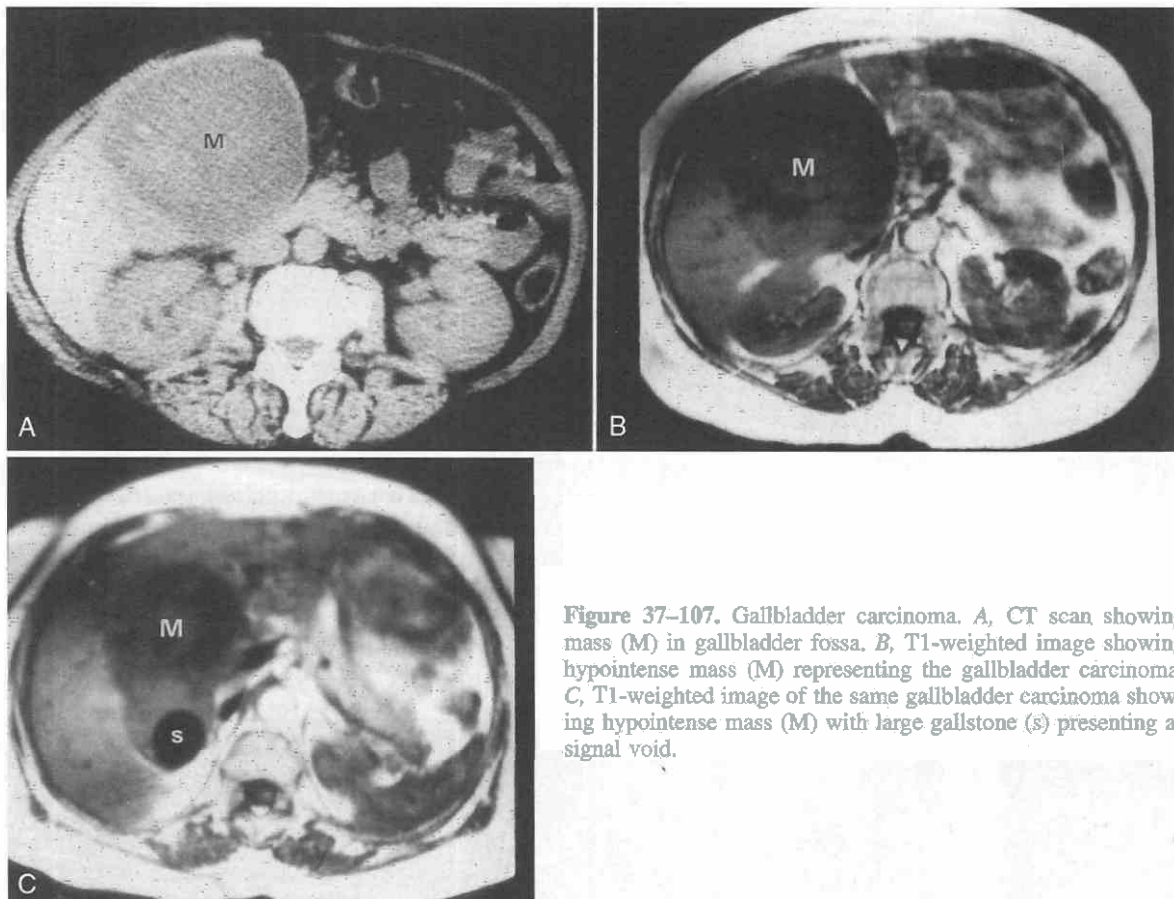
Gallbladder carcinoma. *A*, CT scan showing mass (*M*) in gallbladder fossa. *B*, T1-weighted image showing hypointense mass (*M*) representing the gallbladder carcinoma. *C*, T1-weighted image of the same gallbladder carcinoma showing hypointense mass (*M*) with large gallstone (*s*) presenting as signal void.
